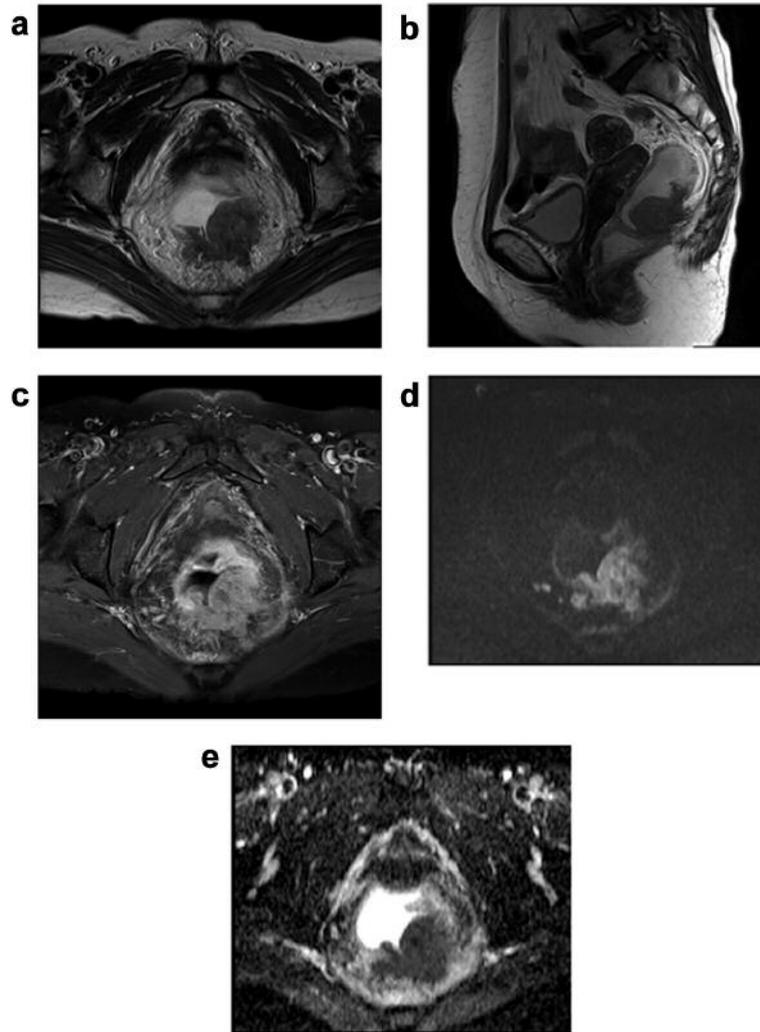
A 64-year-old female patient with rectal cancer with Kirsten-ras (*KRAS* mutation). T2-Weighted turbo-spin-echo oblique axial (a) and T2-weighted sagittal (b) magnetic resonance images, both showing rectal mass with a polypoid pattern, a relatively long axial tumor length (2.8 cm), and a relatively large ratio of the axial to the longitudinal dimensions of the tumor (0.7). Several enlarged lymph nodes were observed in the mesorectum along the superior rectal vessel, suggesting N2 stage. c: An axial contrast-enhanced T1-weighted magnetic resonance image, showing a rectal tumor with penetration through the rectal wall into the mesorectal fat and fascia. d: The rectal mass exhibited a high signal intensity on the diffusion-weighted image ($b=1,000$ s/mm²). e: An apparent diffusion coefficient map, showing diffusion restriction.
